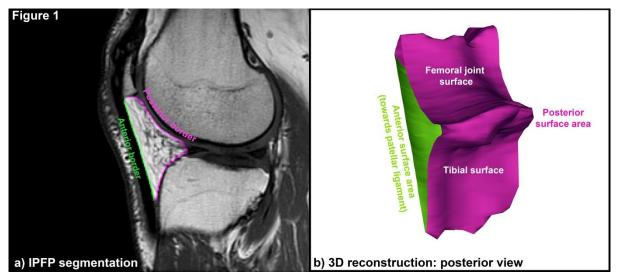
a) Sagittal MR image of the knee joint with segmentation of the infrapatellar fat pad (IPFP) anterior surface (green, facing the patellar ligament) and posterior surface (magenta, facing the inferior patellar pole, the distal femur and proximal tibia). b) 3D reconstruction of the IPFP from a posterior viewing angle. The anterior surface area is colored in green and the posterior surface area is colored in magenta.
